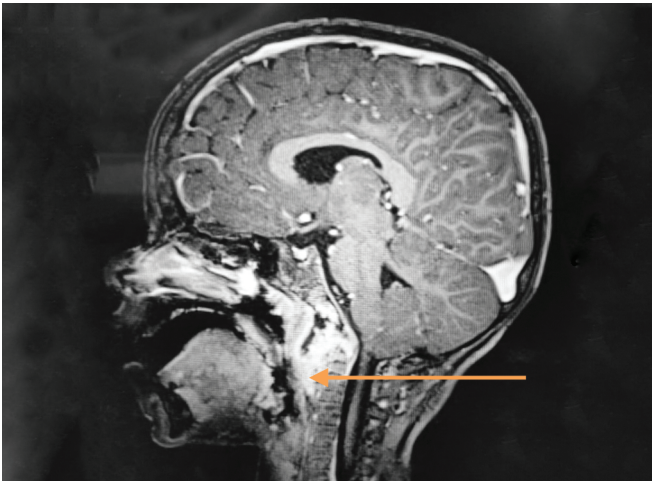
Post contrast CT enhancement (sagittal view) showing retropharyngeal abscess
